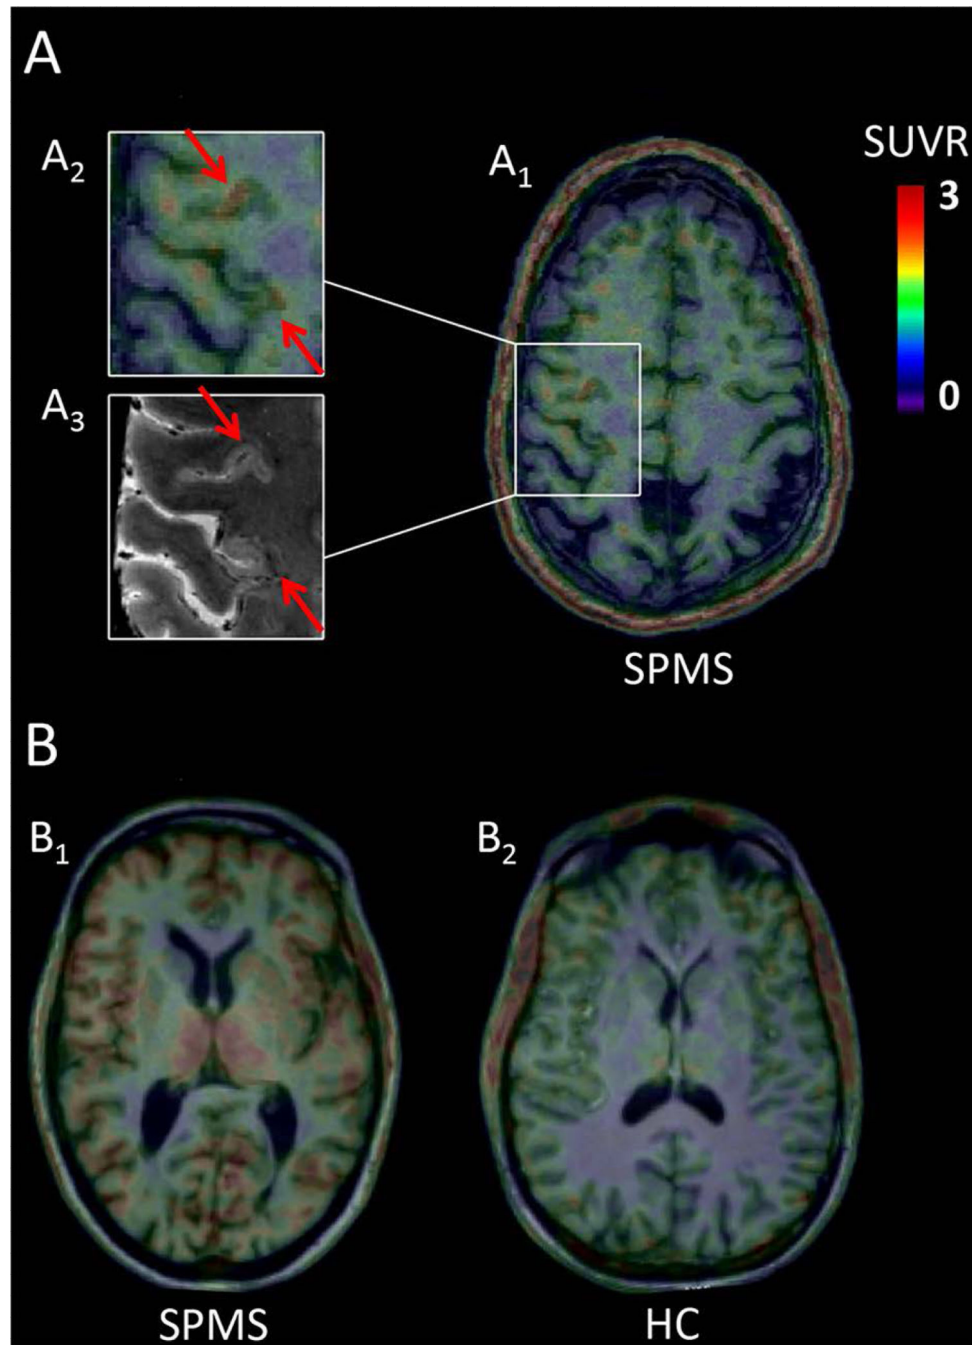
A) Fused magnetic resonance and positron emission tomography (MR-PET) images in a subject with secondary-progressive multiple sclerosis (SPMS) and a high affinity binding (HAB) genotype (A₁) showing cortical areas of increased ¹¹C-PBR28 standardized uptake values normalized by a pseudo-reference region (SUVr). (A₂) Detail of cortical lesions visible on the 3 Tesla (T) anatomical scan fused with SUVr images and (A₃) on the co-registered 7T T₂* images. B) Fused ¹¹C-PBR28 SUVr MR-PET images in a HAB MS
